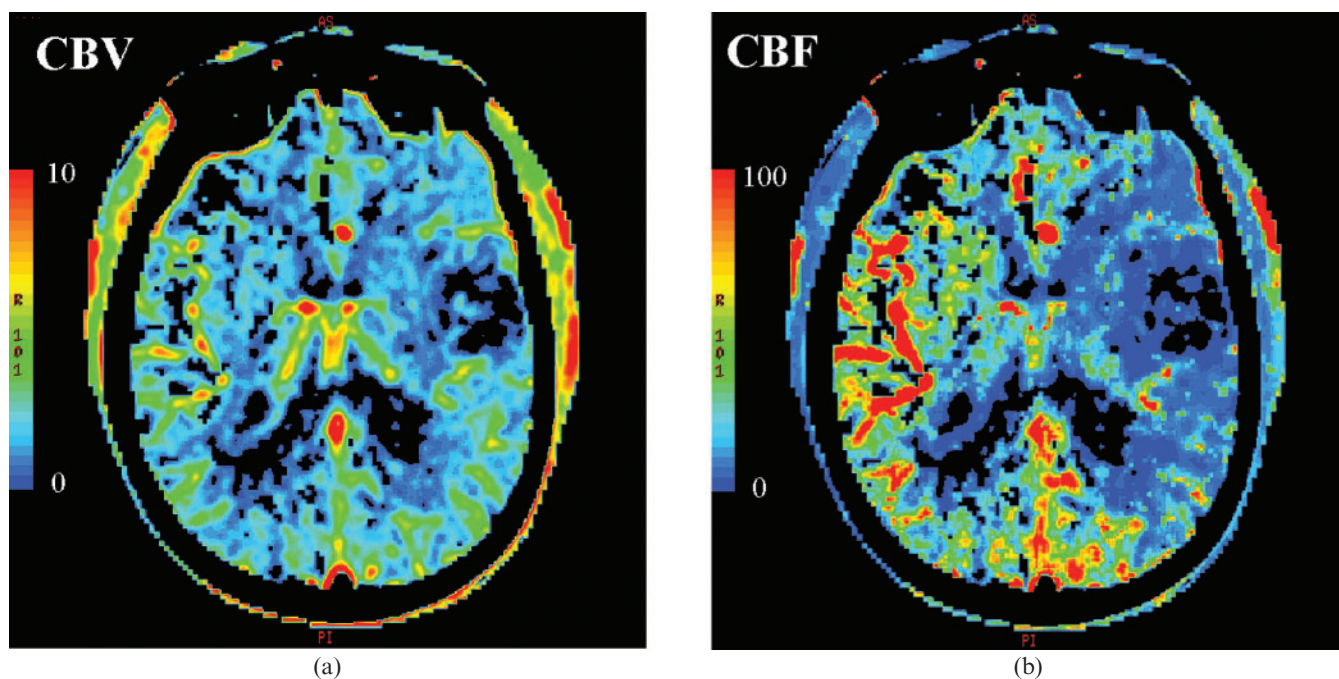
Cerebral Perfusion CT. (a) Cerebral blood volume (CBV) and (b) cerebral blood flow (CBF), mismatch post stroke suggestive of extensive penumbra.
